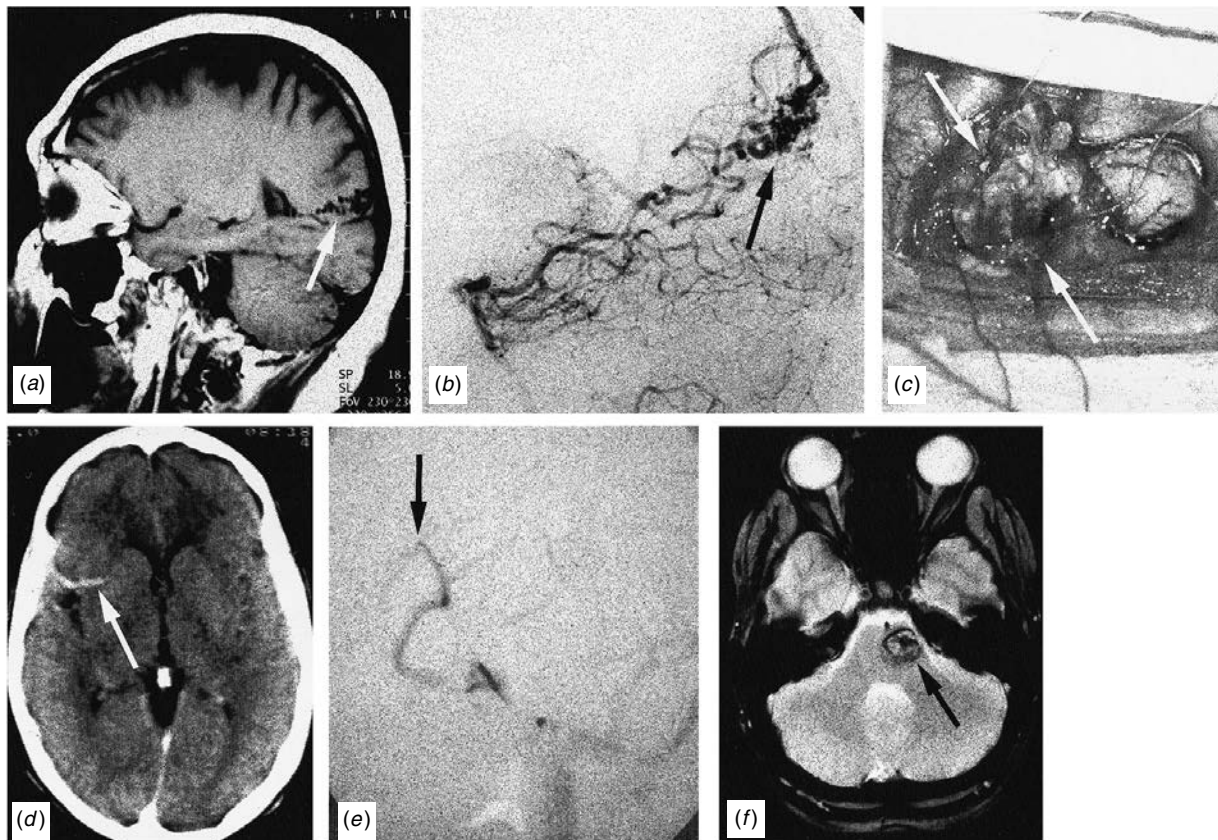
Imaging studies of vascular malformations. (a) Sagittal T_1 -weighted MRI demonstrating a parieto-occipital arteriovenous malformation (arrow) with the apex of the lesion reaching the occipital horn of the lateral ventricle. (b) Same case as (a). A vertebral angiogram shows filling of the malformation (arrow) and venous drainage to the superficial and deep venous systems. (c) Same case as (a) and (b). The malformation has been dissected from the surrounding brain (arrows) and is about to be detached from its superficial and deep venous attachments, which is the last step in removing the lesion. (d) CT scan with contrast demonstrating an enhancing vascular lesion in the right Sylvian fissure (arrow). On venous phase carotid angiography (e), this was revealed as a venous malformation with a typical 'Caput Medusae' appearance. (f) MR scan revealing a large cavernous malformation in the left side of the pons.
